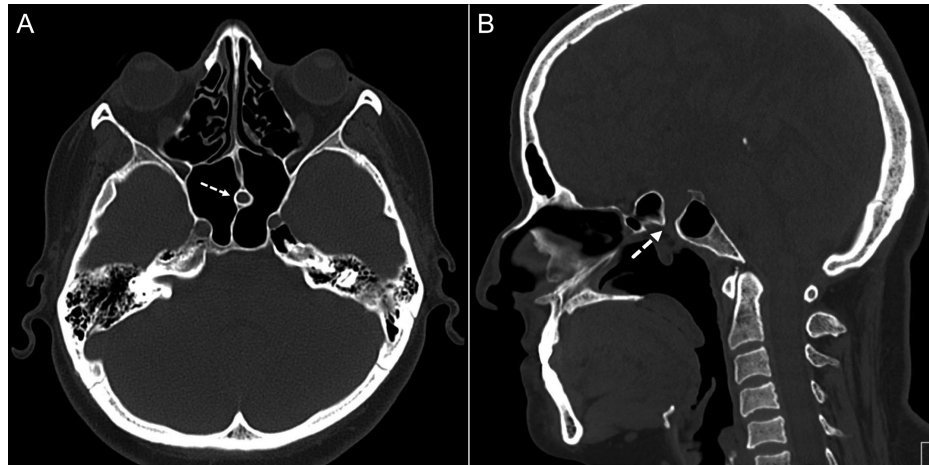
(A, B) CT (axial–sagittal), Persistent craniopharyngeal canal (dashed arrow) and protrusion of the adenohypophysis into the nasopharyngeal space. CT, computed tomography.
